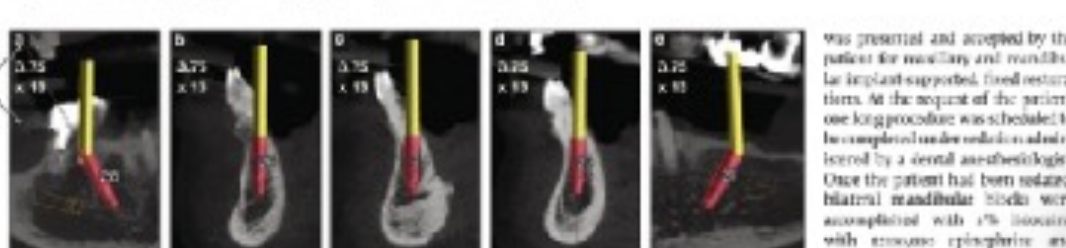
CBCT imaging of maxilla and mandible showing implant sites.
